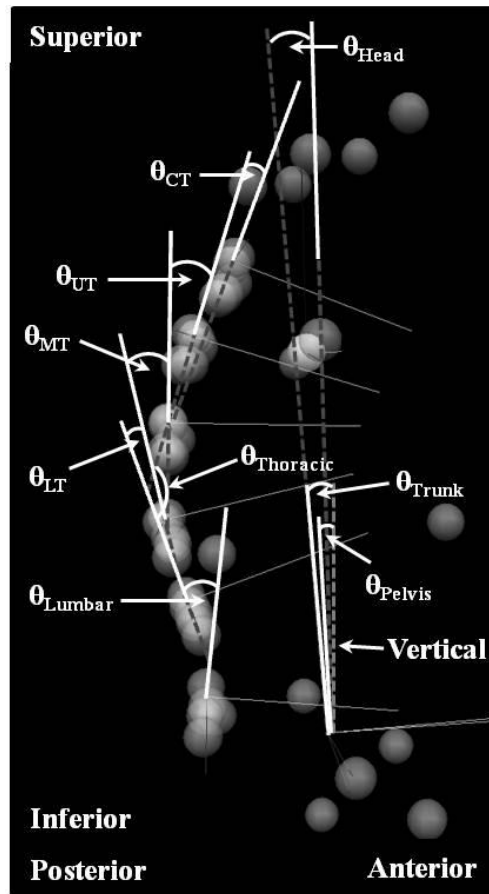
Collapsed 3D sagittal view of the markers representing the calculation of each angle. The angles represented in this collapsed 3D sagittal view are the equivalent of flexion-extension angles. CT: cervico-thoracic; UT: upper-thoracic; MT: mid-thoracic; LT: lower-thoracic (Adapted, by permission, from: Schinkel-Ivy A, Pardisnia S, Drake JDM. Head and arm positions that elicit maximal voluntary trunk range-of-motion measures. *Journal of Applied Biomechanics* 2014 (accepted July 1, 2014). Figure 2c. © Human Kinetics, Inc.). Written copyright permission not required for self-authored work; refer to Appendix B.
